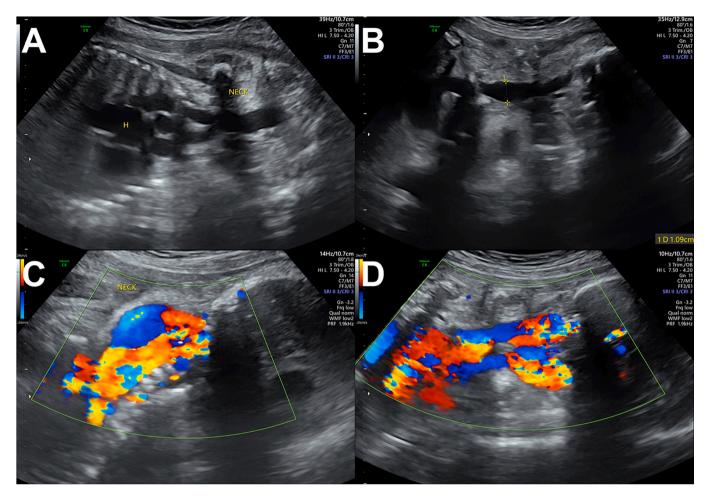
Sagittal two-dimensional ultrasound view of the fetal neck showing dilated fetal neck vessels at a gestational age of 35 weeks. A and B: the fetal neck vessels dilated, measuring 1.09 cm. C and D: Color Doppler shows a full blood flow signal in the neck area.
